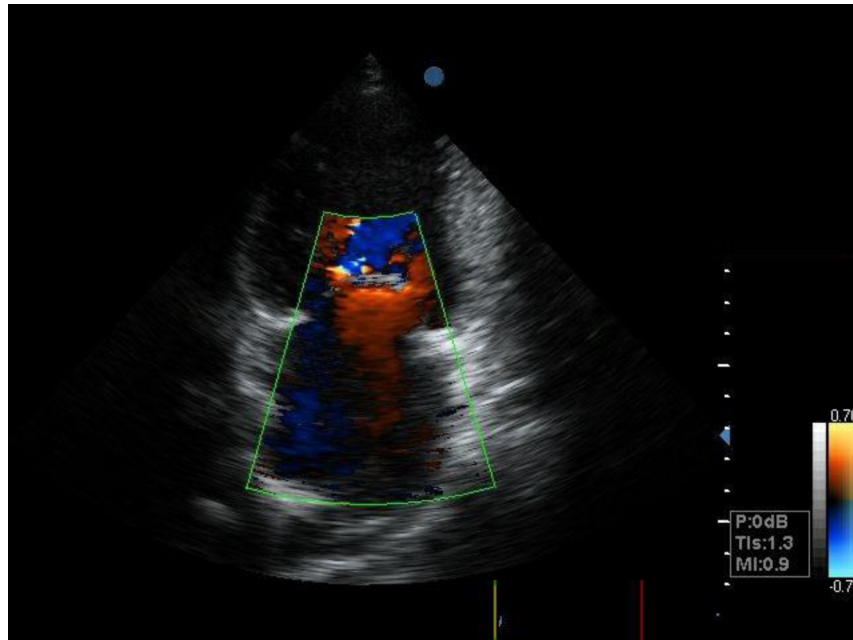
Ultrasound scan showing regurgitant blood flow due to mitral valve insufficiency
